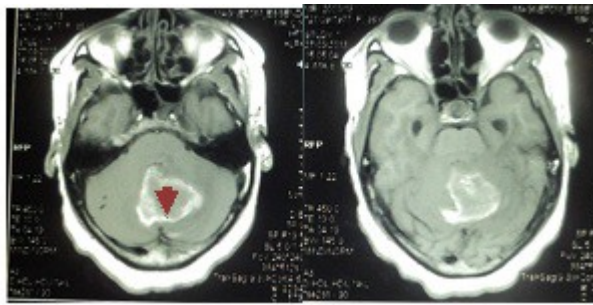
Pre- and post- contrast enhanced T1 weighted MRI images showing a hyperintense midline cerebellar mass with a hypointense core (arrow-head), minimal perilesional edema and mild enhancement with contrast.
